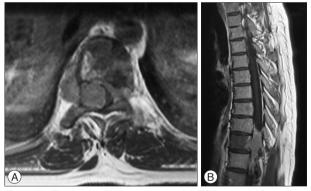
A : T1-weighted, postcontrast axial MR image performed 13 years later despicts progression of the former lesion at D10 vertebral level with extension into the extradural space on the right and crossing of the midline towards the leftside. B : T1-weighted, postcontrast sagittal image also shows involvement of the D10 vertebral body with low signal intensity due to tumor cell infiltration.
